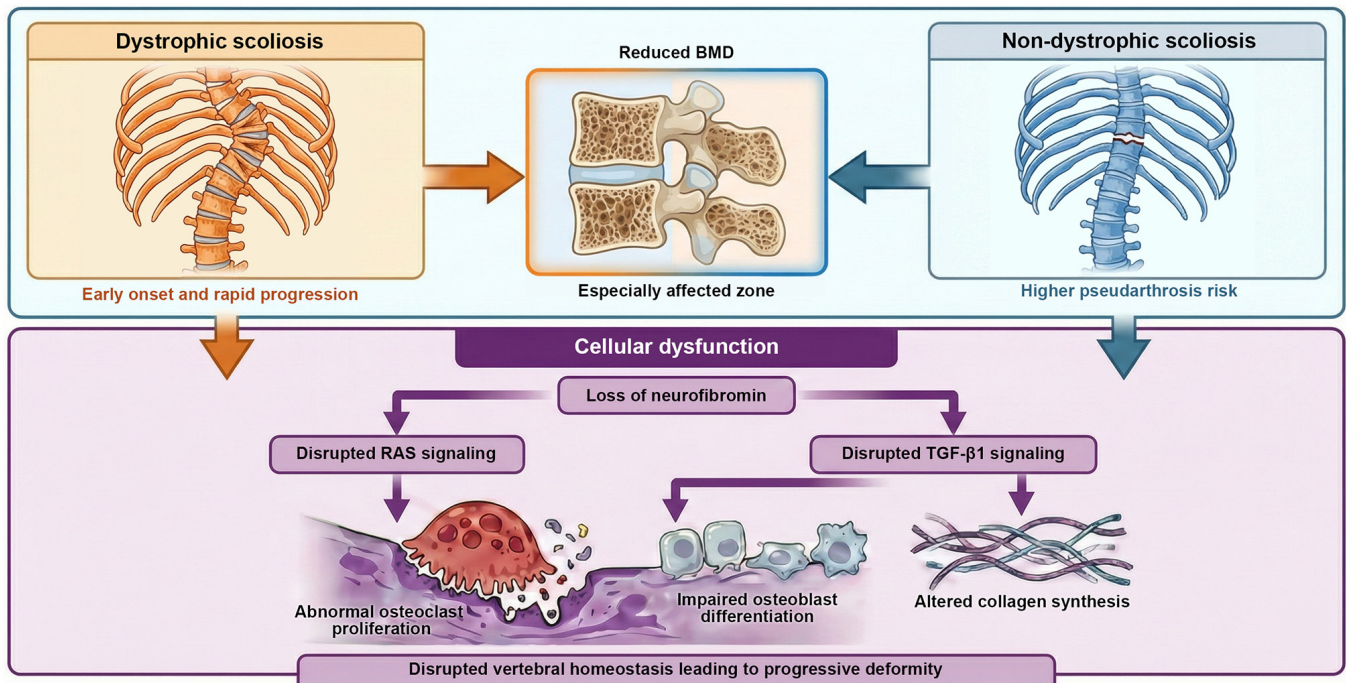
Clinical classification and cellular pathogenesis of NF1-associated scoliosis. NF1-associated scoliosis is generally classified into dystrophic and non-dystrophic forms, which differ in radiographic features, progression pattern and clinical risk. Dystrophic scoliosis represents the characteristic spinal deformity in NF1, and is typically marked by early onset, rapid progression and frequent involvement of the upper thoracic spine. By contrast, non-dystrophic scoliosis may initially resemble adolescent idiopathic scoliosis but can progress. Non-dystrophic scoliosis is associated with an increased risk of complications, including pseudarthrosis after spinal fusion. In addition to focal spinal deformity, patients with NF1 often exhibit systemic reduced BMD, with the lumbar spine disproportionately affected, suggesting that spinal instability occurs in the context of generalized skeletal fragility. At the cellular and molecular levels, neurofibromin deficiency disrupts key signaling pathways that regulate vertebral bone remodeling, including RAS/MAPK and TGF- $\beta$ 1 signaling cascades. These changes promote abnormal osteoclast proliferation, impair osteoblast differentiation and alter collagen biosynthesis. Together, these abnormalities disturb vertebral bone homeostasis, and provide a mechanistic basis for reduced BMD, progressive spinal deformity, impaired fusion biology and the clinical severity of NF1-associated scoliosis. NF1, neurofibromatosis type 1; BMD, bone mineral density.
